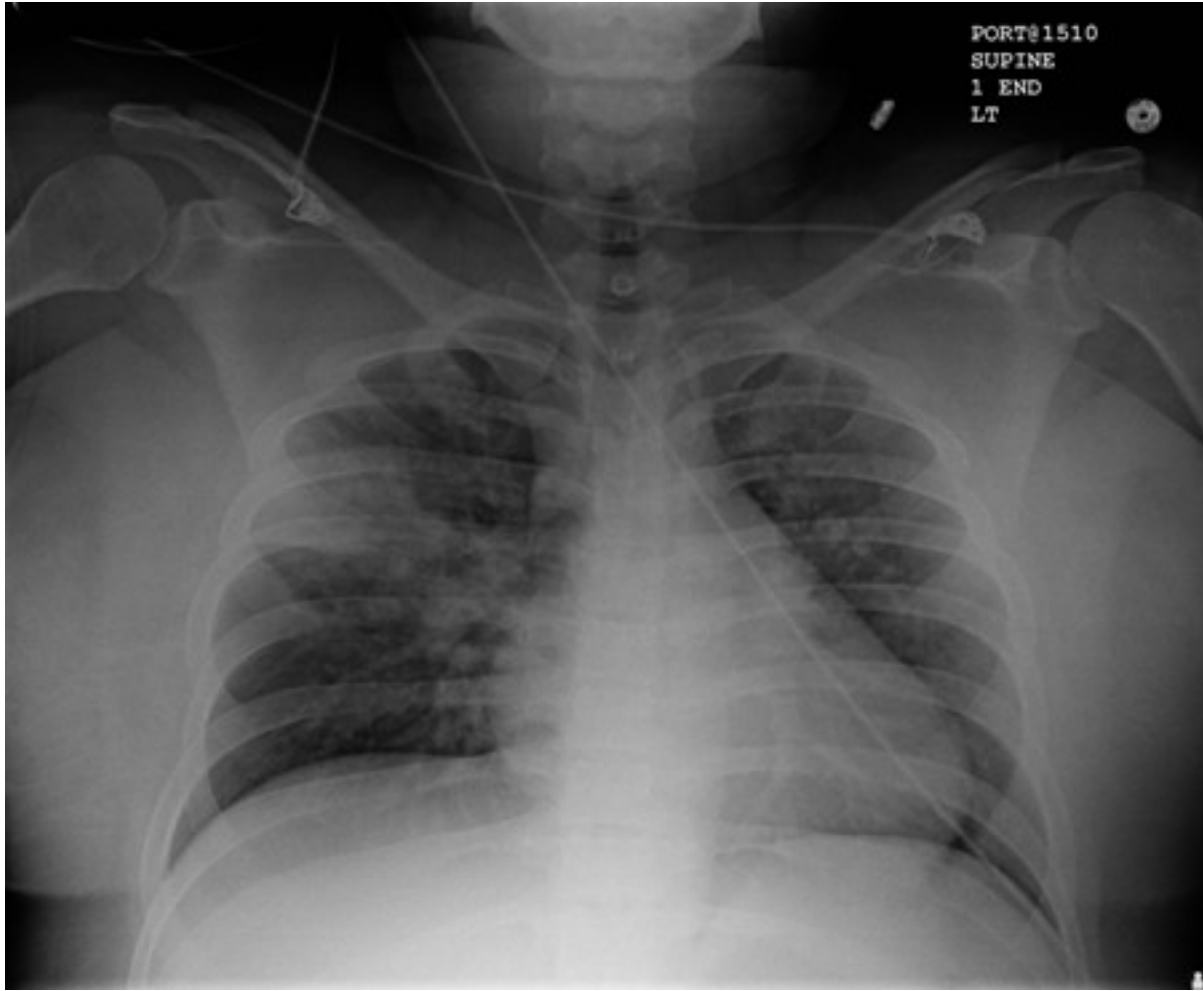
Chest x-ray with dilated and thickened airways in a patient with bronchiectasis*
